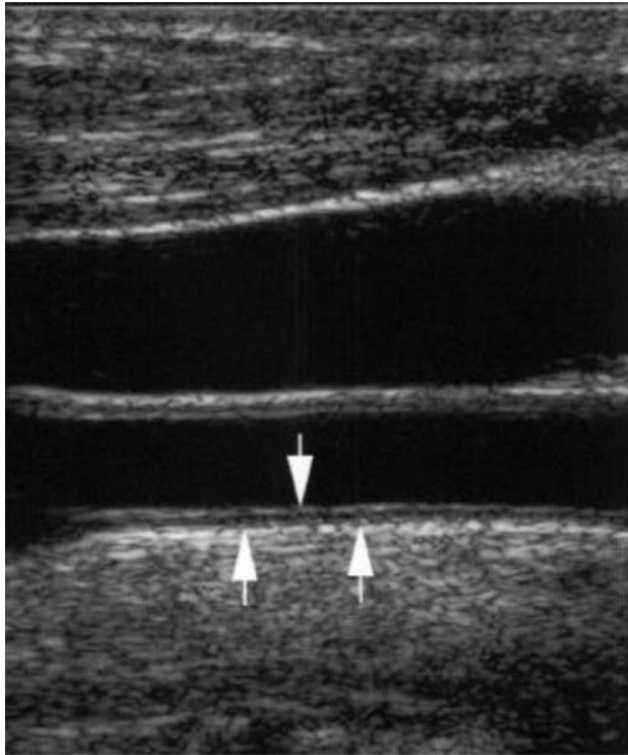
Ultrasound B-mode image showing intima-media complex (between the arrows).
